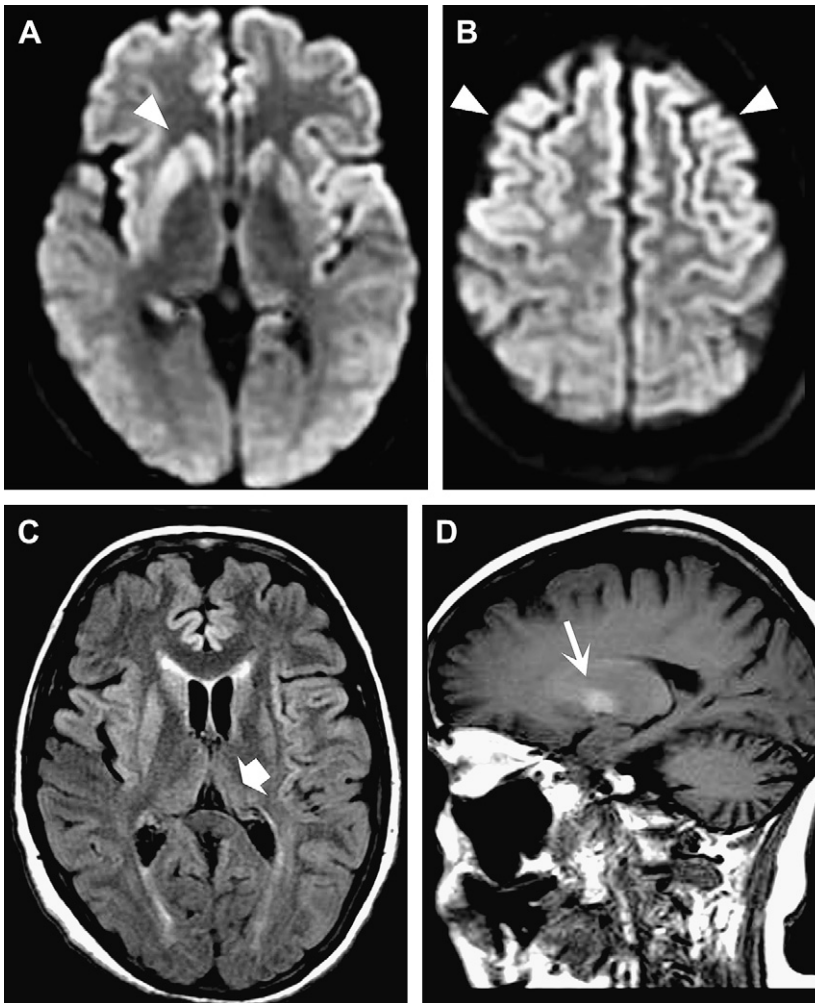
Sporadic Creutzfeldt-Jakob disease in 52-year-old woman, previously healthy, who has rapidly progressive dementia and mutism. Axial diffusion-weighted images (A, B) shows striatal and cortical restricted diffusion (arrowheads) with corresponding hyperintensity on fluid-attenuated inversion recovery (FLAIR) (C). Note the medial thalami are also hyperintense on FLAIR (solid arrow), but it is less pronounced than the striatal abnormalities. Sagittal T1-weighted image (D) shows pallidal hyperintensity (thin arrow), which may relate to prion protein accumulation.
